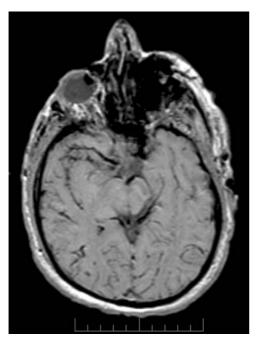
Massive gas embolism is seen in the right middle cerebral artery, the left internal carotid artery, and the left posterior cerebral artery (T1-weighted 5 mm section, TR 270 ms, TE 4.2 ms)
